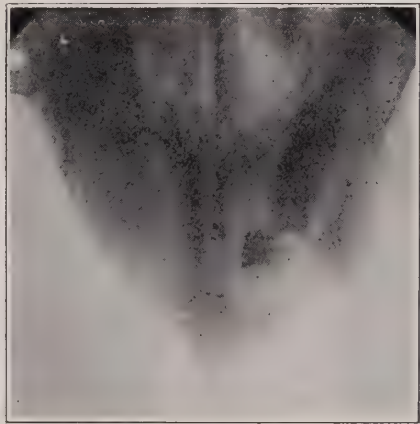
Roentgenogram showing impacted maxillary cuspid in patient 75 years old. Patient had been wearing a full upper denture for thirty years. Destruction of the osseous tissue over the tooth and of the crown of the tooth developed; a fistula was evident in the palate.
